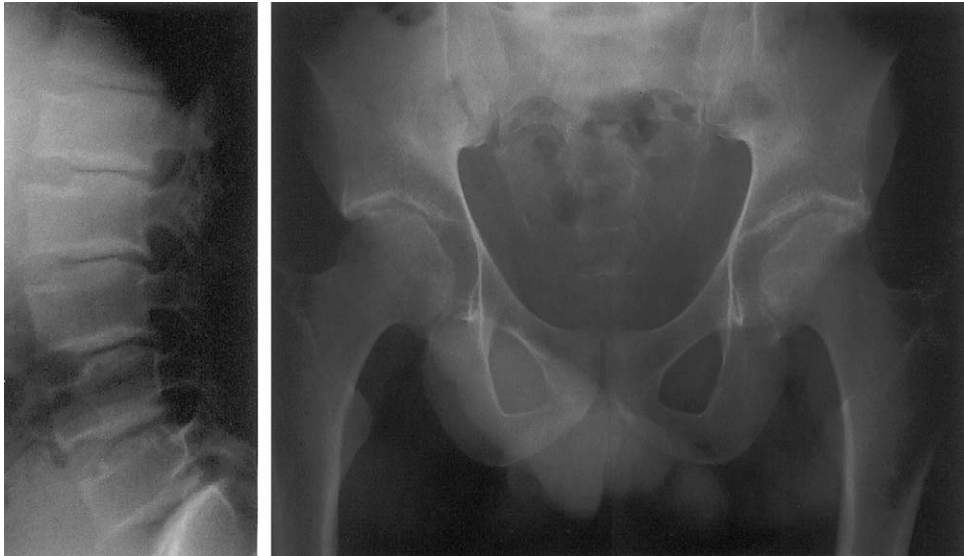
Radiographs of the lateral spine (*left*) and pelvis (*right*) of a 31-year-old man (IV:8 in fig. 1) with SEDL. Note platyspondyly and superior and inferior humping of vertebrae, as well as irregular hip-joint surfaces and short femoral necks.
